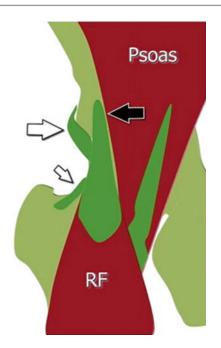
Anatomy of the proximal rectus femoris. *RF* rectus femoris, *black arrow*=direct tendon and its insertion on the anteroinferior iliac spine; *white arrow*=indirect tendon and its insertion on the lateral aspect of the acetabular rim; *small white arrow*=reflected tendon and its insertion on the anterior articular plane. Reproduced from Pasta G, Nanni G, Molini L, Bianchi S. Sonography of the quadriceps muscle: Examination technique, normal anatomy, and traumatic lesions. J Ultrasound. 2010;13:76–84. Copyright© 2010 Elsevier. All rights reserved
